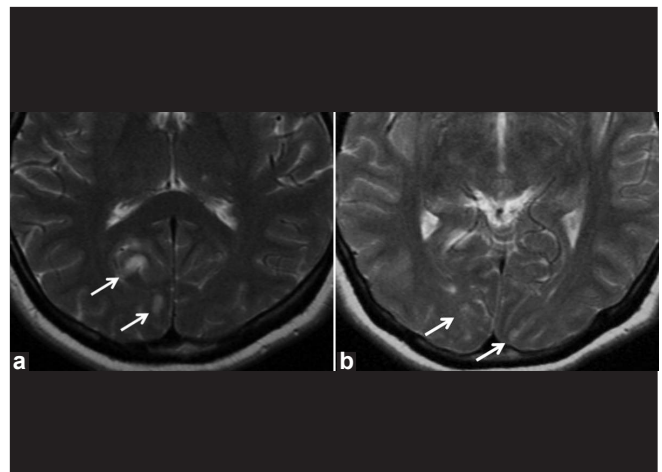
(a and b) Axial T2-weighted images showing hyperintense areas compatible with the acute infarct involving the striate and extrastriate cortex (arrows)
